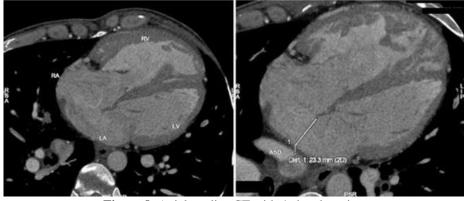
Axial cardiac CT with 4 chamber view
